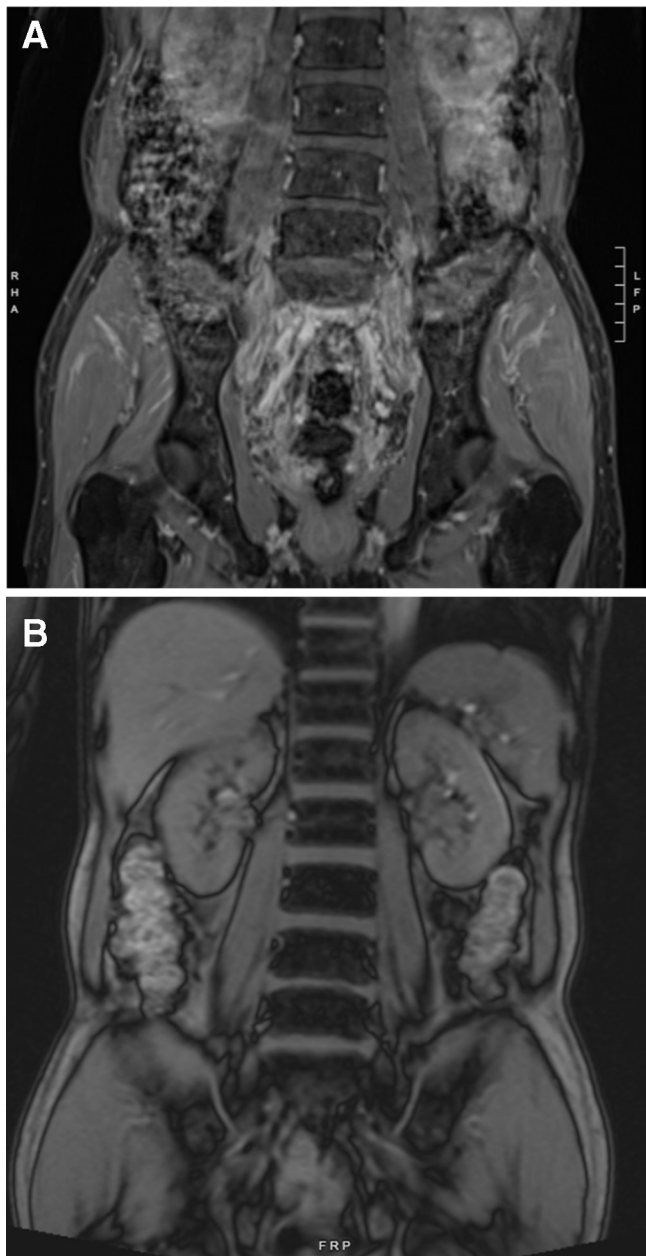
(A) Patient's initial MRI findings before dupilumab treatment showed extensive retroperitoneal and extraperitoneal fibrosis. (B) MRI taken approximately 1 year after dupilumab treatment showed dramatic resolution of fibrosis.
